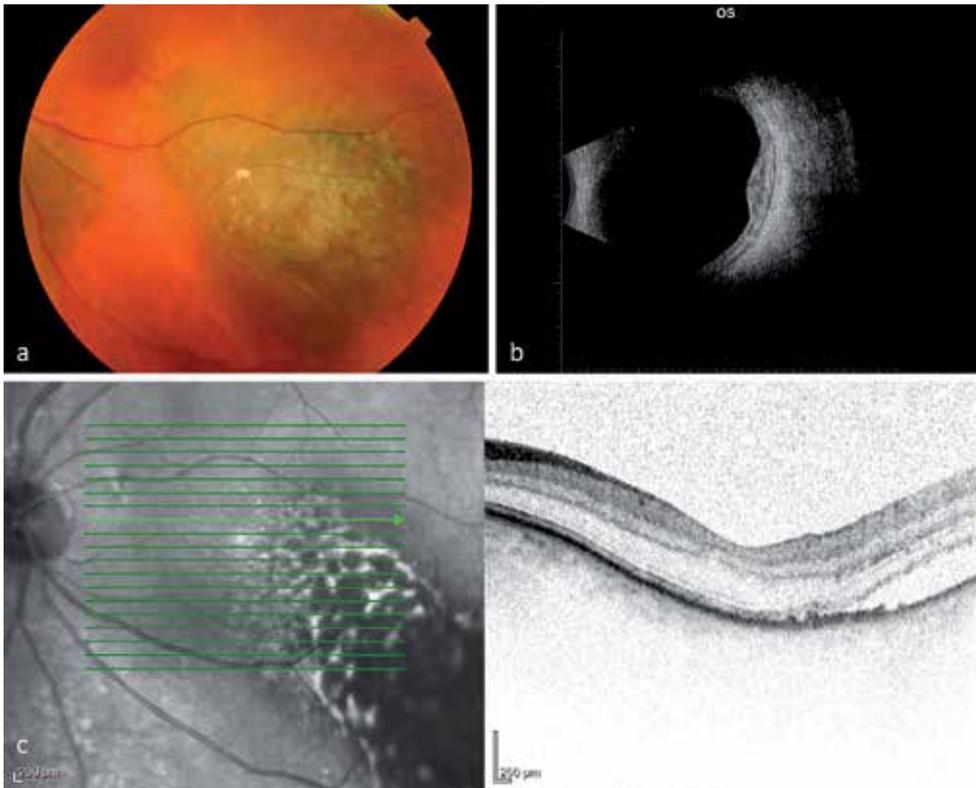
a: Pigmented uveal melanoma with orange pigment (lipofuscin); 3b: A homogeneous grey scale in the tumour and choroidal excavation on B-scan ultrasonography; 3c: Optical coherence tomography of the same tumour with subretinal fluid.
